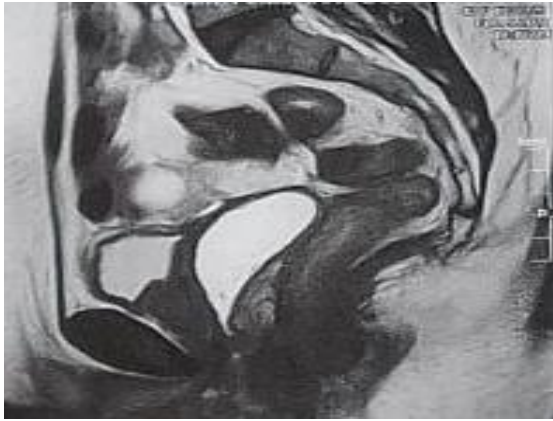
Pelvic magnetic resonance imaging with extensive lesion in the anterior wall
